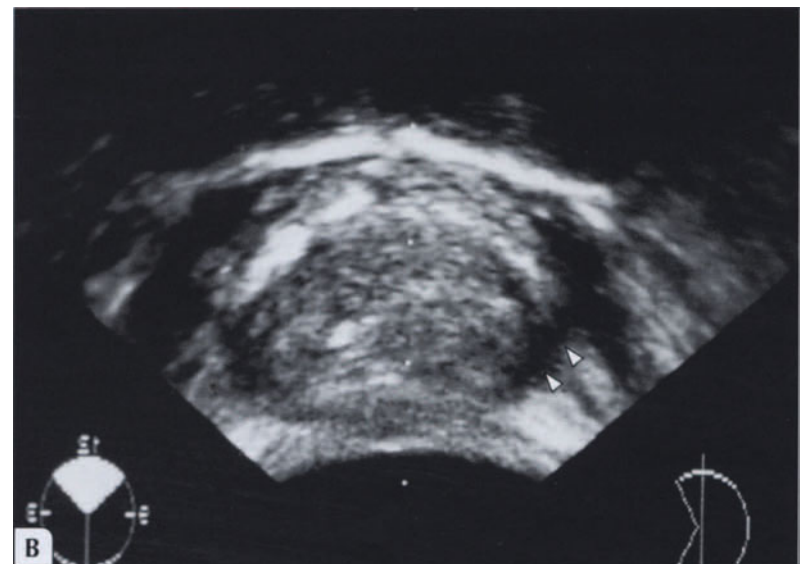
Transrectal ultrasound images before and after treatment. A, Transverse, transrectal ultrasound view of a localized prostate cancer before cryoablation. A hypoechoic area representing the cancer is seen in the left peripheral zone (*arrow*). B, Six months after cryoablation, the prostate is significantly smaller
